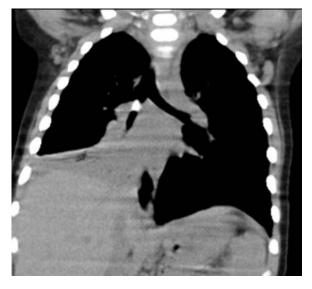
Axial CT section obtained with mediastinal window; a hyperdense lesion in the bronchus of right lower lobe, causing complete obstruction and atelectasis in lower lobe. Chicken bone was identified in bronchoscopy.
